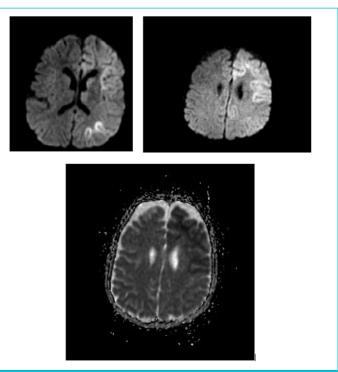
Diffusion restriction in favor of edema in the cortical and juxtacortical areas in the left frontal and left occipital lobes in diffusion magnetic resonance imaging.
